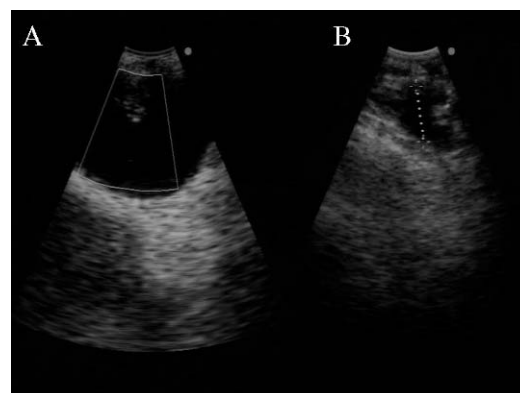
Ultrasound-guided bronchoscopy of the right paratracheal cyst: A) before puncture, in Doppler mode; and B) after draining.
